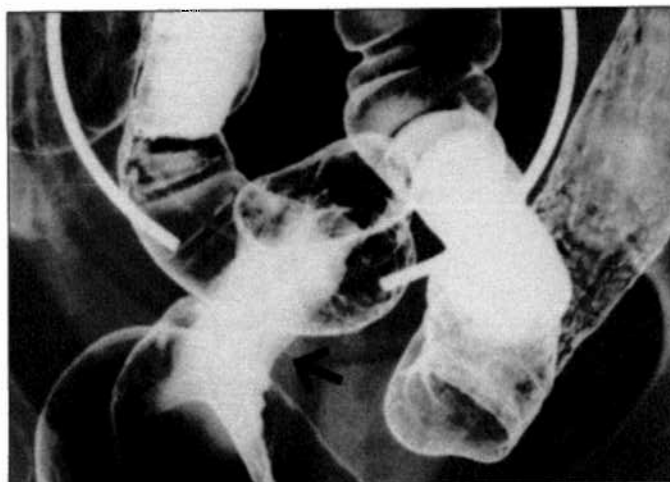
Frontal spot radiograph with compression of the sigmoid colon demonstrates an area of narrowing (arrow) that involves a larger segment of bowel than the previous example.
